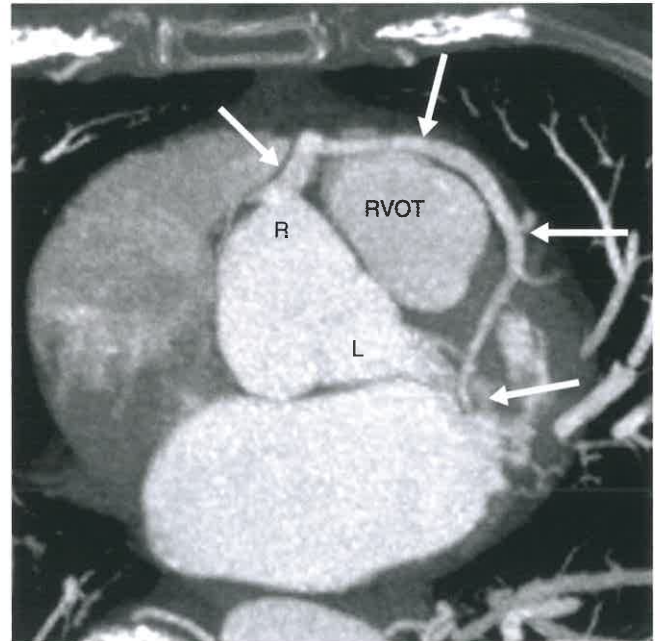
Prepulmonic Course. Axial oblique image from a coronary CTA shows that the left main coronary artery (white arrows) arises from the right sinus of Valsalva (R) and courses anteriorly around the right ventricular outflow tract (RVOT), consistent with a prepulmonic or precardiac course. No coronary artery arises from the left sinus of Valsalva (L). This is a benign anomaly.
